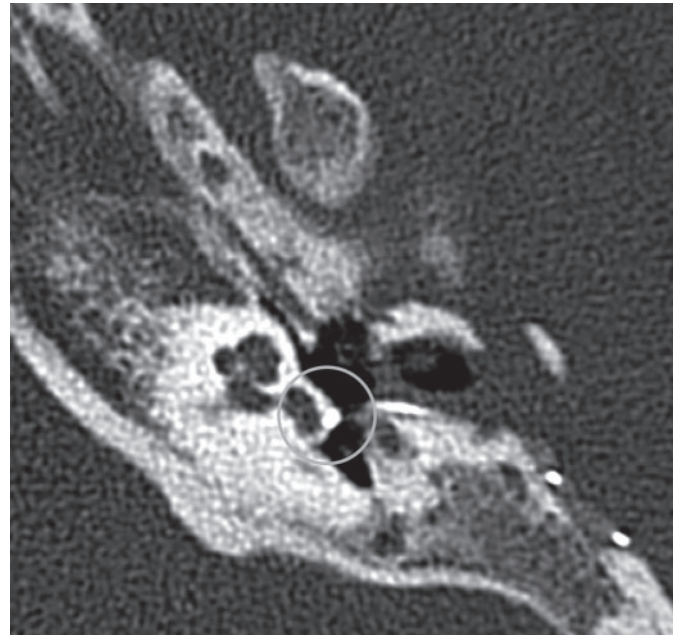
Postoperative CT scan with FMT placed at the round window (circle).
